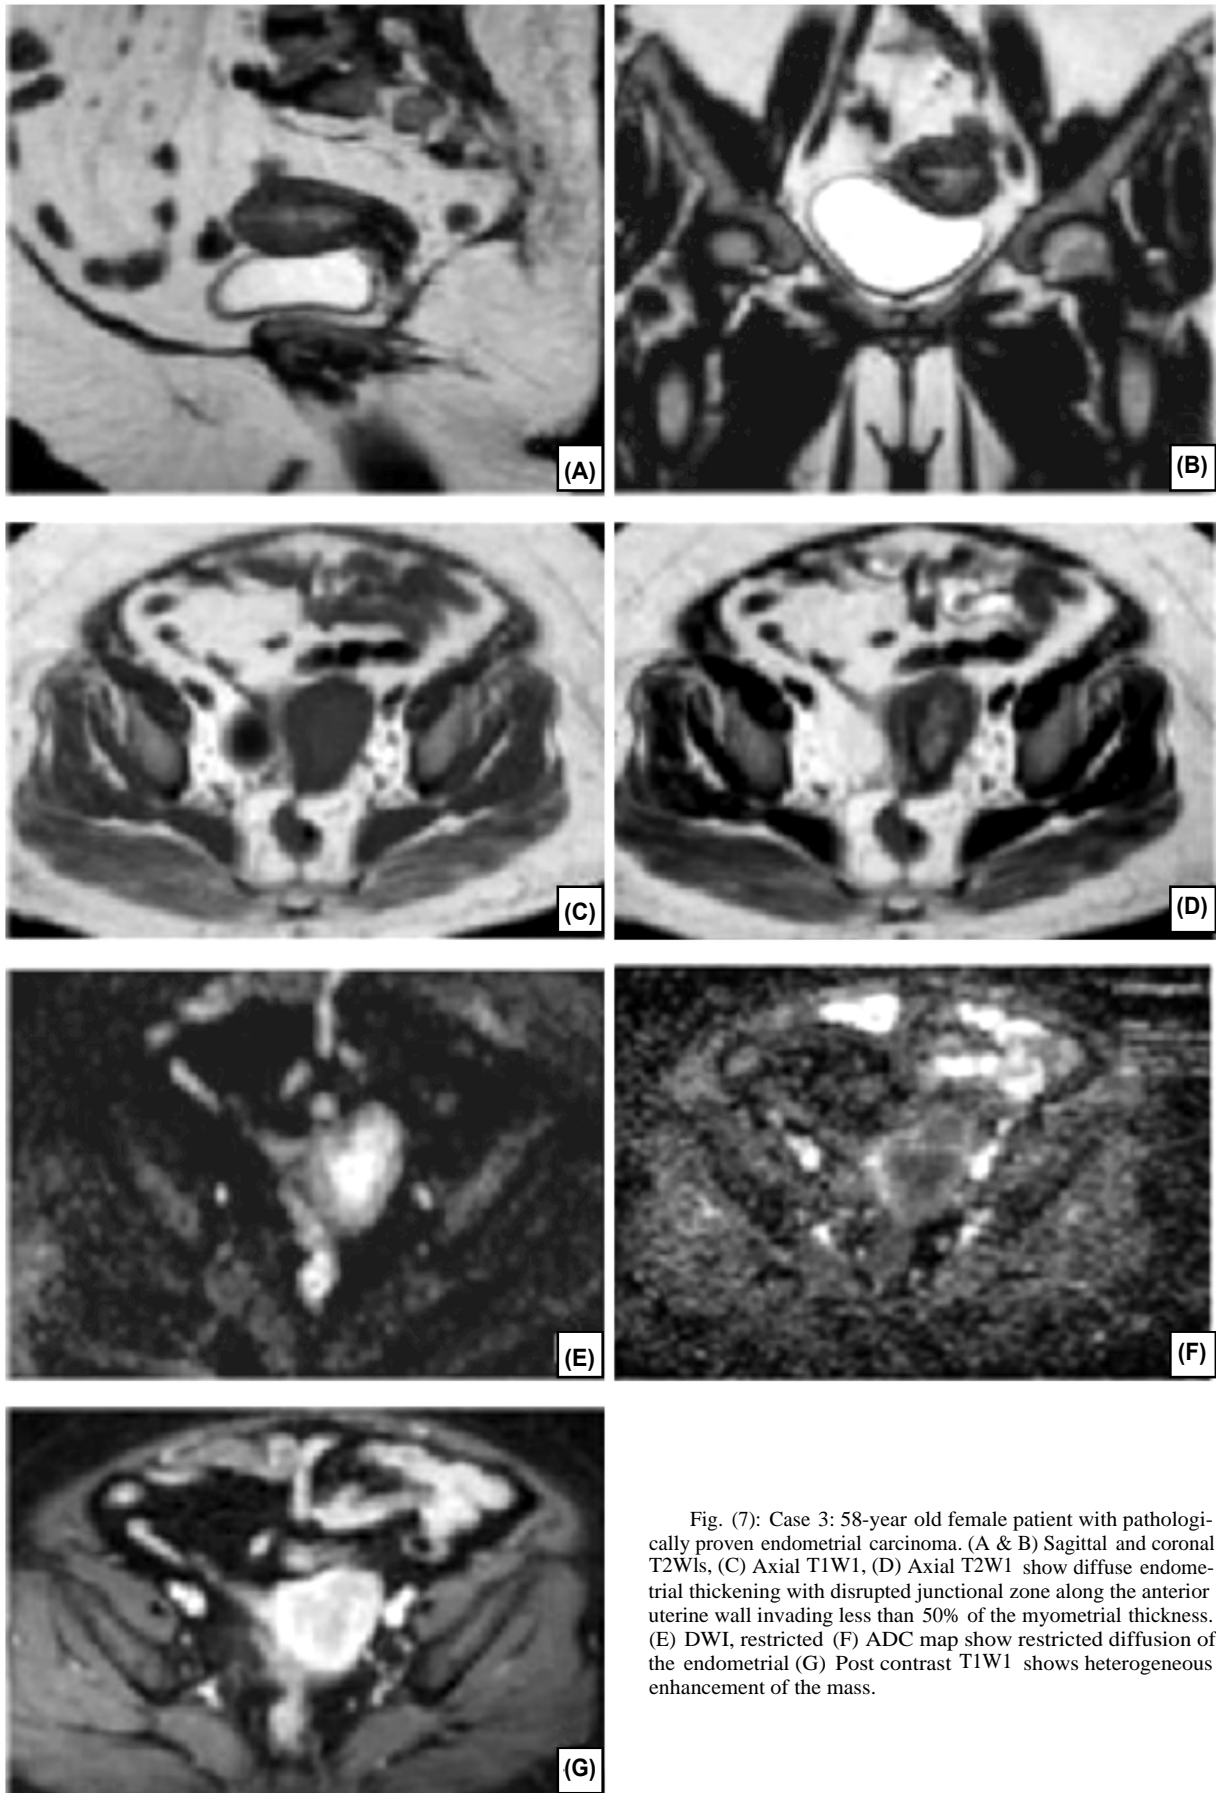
Case 3: 58-year old female patient with pathologically proven endometrial carcinoma. (A & B) Sagittal and coronal T2WIs, (C) Axial T1W1, (D) Axial T2W1 show diffuse endometrial thickening with disrupted junctional zone along the anterior uterine wall invading less than 50% of the myometrial thickness. (E) DWI, restricted (F) ADC map show restricted diffusion of the endometrial (G) Post contrast T1W1 shows heterogeneous enhancement of the mass.
